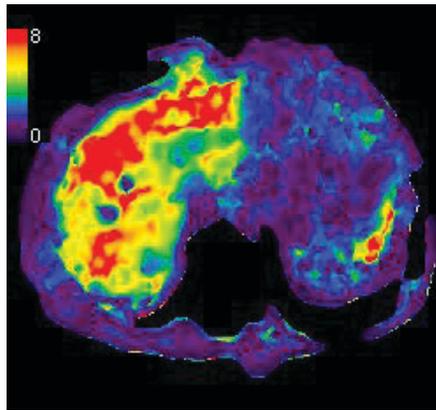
MRI with elastogram.
